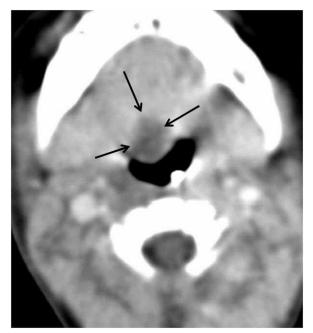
Case 2. Axial contrast-enhanced computed tomography (CT) image showing a rounded minimally enhancing low attenuation mass (arrows) at the base of the tongue protruding into and causing some obliteration of the airway.
